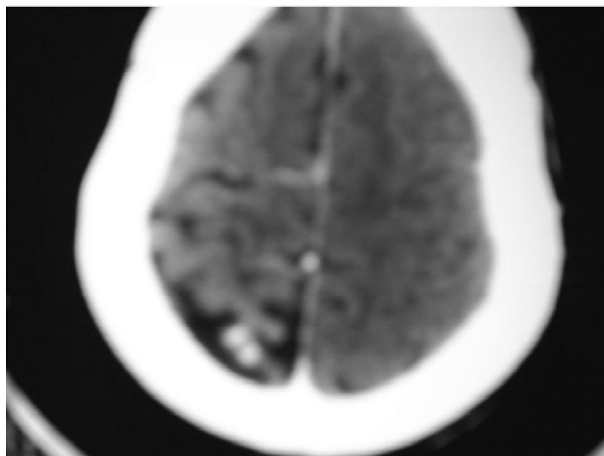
CT brain- left occipital angioma and calcification
